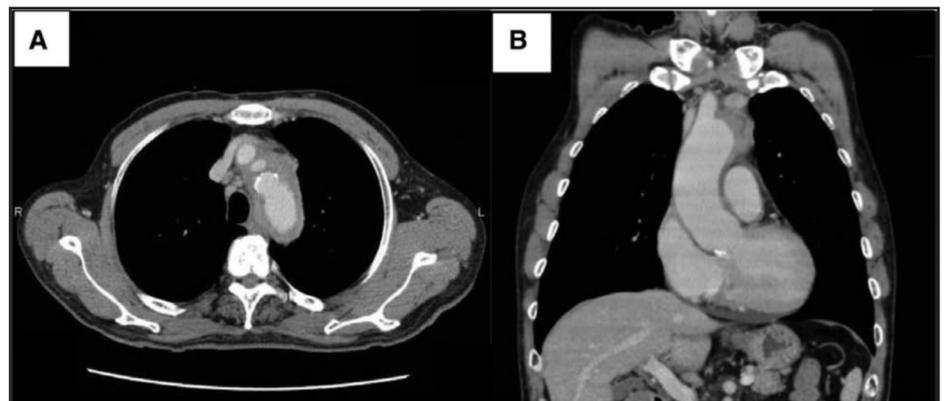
Chest CT at first visit. A, Axial view, B, coronal view. Around the aortic arch, left common carotid artery and left subclavian artery, there was an abnormality that was highly suspected as cancer. CT, computed tomography.
